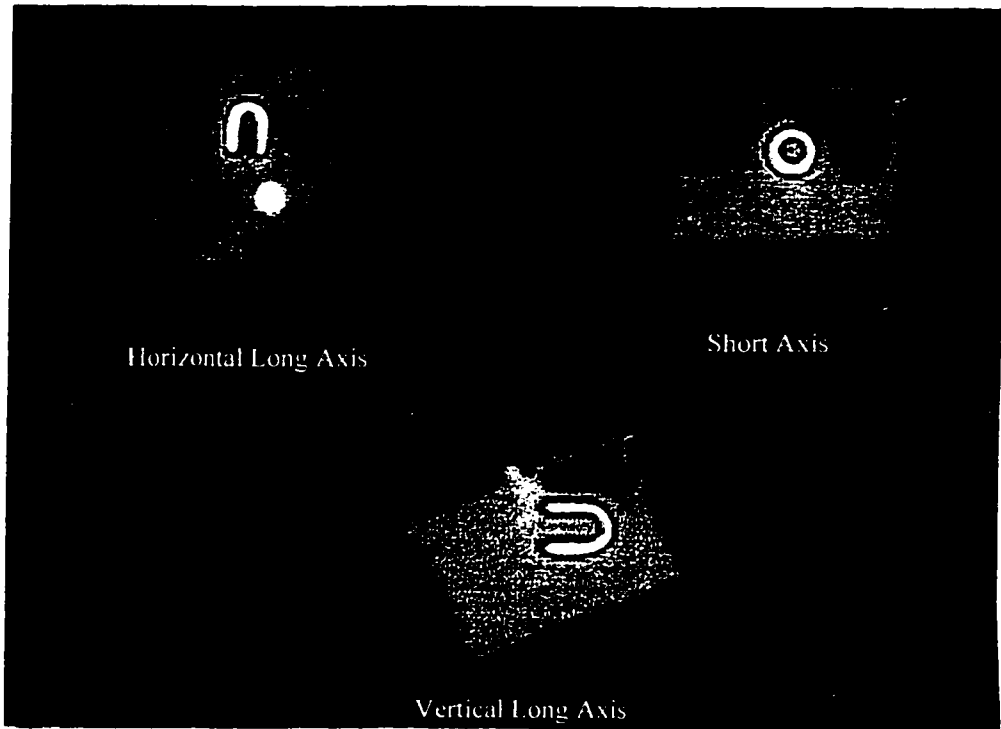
CT attenuation map and registered UNIF (OSEM CT) images shown overlaid. Horizontal Long Axis, Short Axis, Vertical Long Axis.
